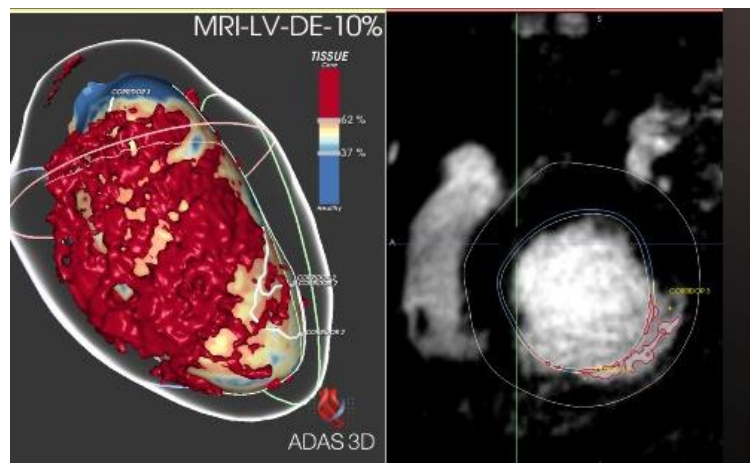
Screen shot of ADAS 3D LV showing a CC in white, scar core volume in red, BZ in orange and healthy tissue in blue in the 10% layer of the LV (the most endocardial layer) and the correspondence between a point in the 3D view and its position in the MRI [58]
